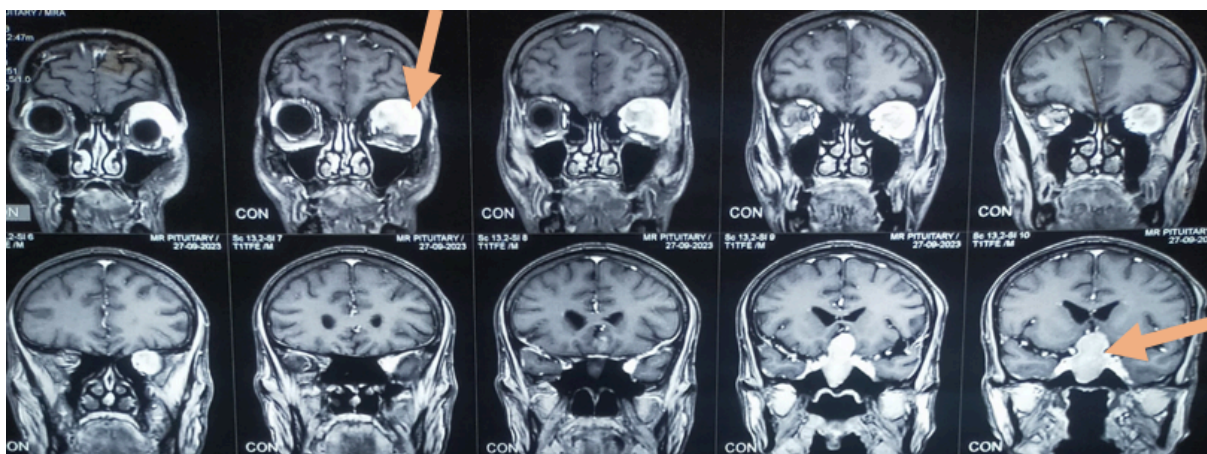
T1-weighted MRI scan with contrast showing a mass in the left orbit and a pituitary mass.
